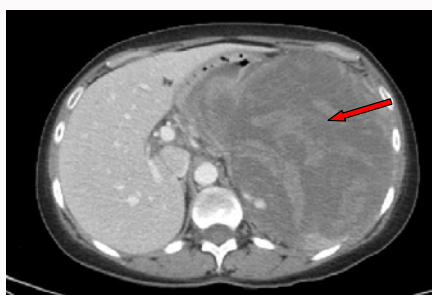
This is an axial image of the CT abdomen and pelvis. The red arrow shows the heterogeneous, predominantly cystic mass in the left upper abdomen measuring greater than 19 cms.
